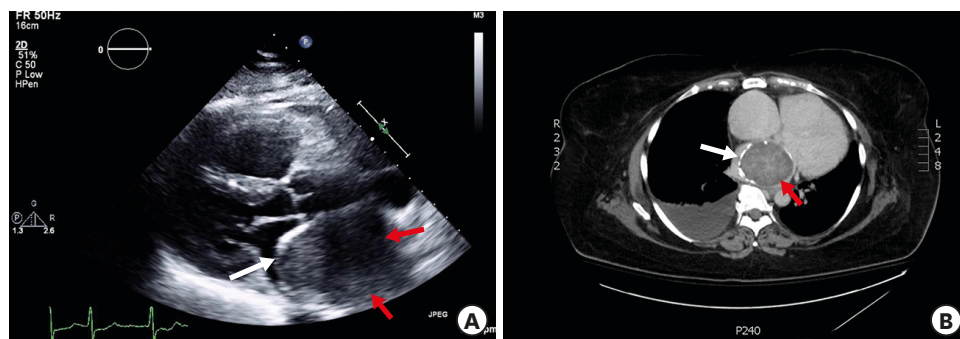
(A) TTE in parasternal long-axis view and (B) pre contrast transverse CT section demonstrating a large soft-tissue mass (red arrows) that virtually fills the entire left atrium, causing it to severely dilate. The presumed myxoma also obstructs left atrial inflow through the pulmonary veins. As a result, the right ventricular cavity is moderately dilated as a way to adapt to the volume and retrograde pressure overload. Note the peripheral calcified rim delineating the tumor (white arrow), a feature that is rarely described in atrial myxomas. CT: computed tomography, TTE: transthoracic echocardiogram.
